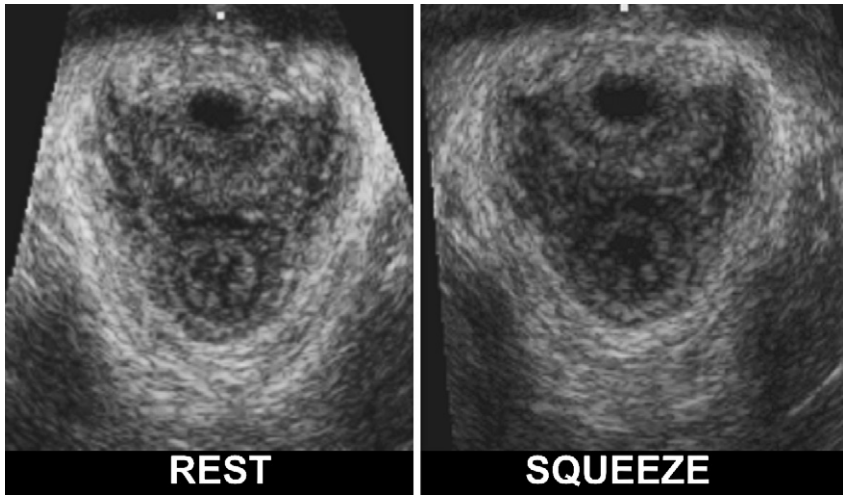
Pelvic Floor Hiatus Captured from the 3D ultrasound images at rest and during a pelvic floor contraction: Note that with contraction the hiatus becomes smaller and the puborectalis muscle moves towards the pubic symphysis. The anterior motion of the puborectalis muscle compresses, anal canal, vagina and urethra against the back of pubic symphysis, which constitutes the constrictor function of pelvic diaphragm. Obtained from author.
